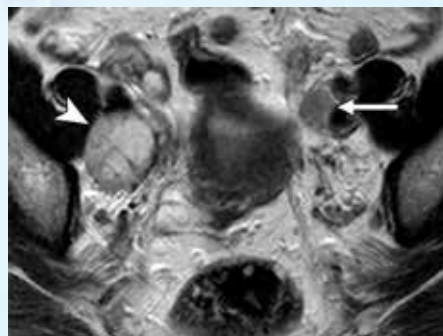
Axial T2-w MRI scan showing enlarged right obturator (arrowhead) and left external iliac lymph nodes (arrow). This is consistent with a stage IIIC1 cancer.
